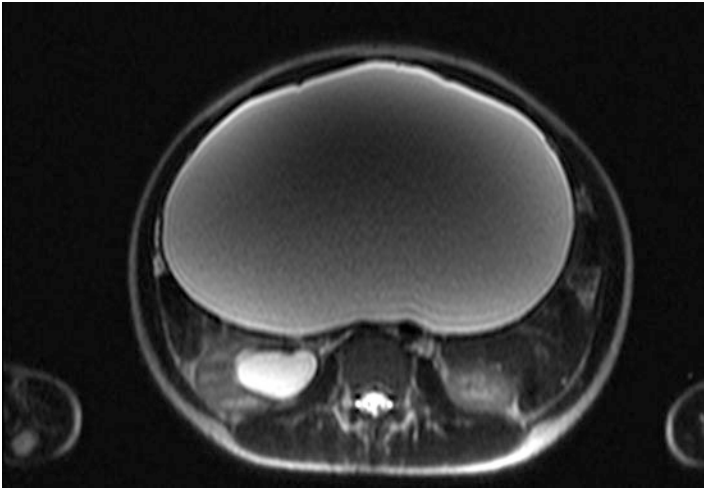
MRI showing a large ovarian benign, simple cyst. Notice the lack of septations and areas of heterogeneity. (Courtesy of Robert Weinsheimer, MD, Swedish Medical Center, Seattle, WA).
